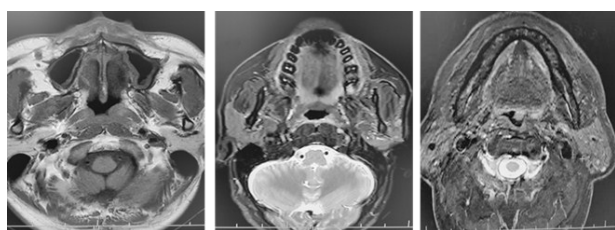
MRI images of a NPC patient. (Male, 48 years old, with a nasopharyngeal mass).
